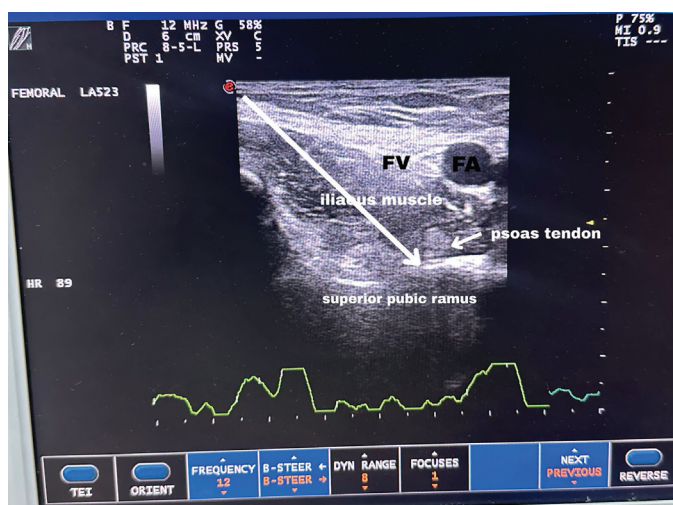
Ultrasound image of pericapsular nerve group block
